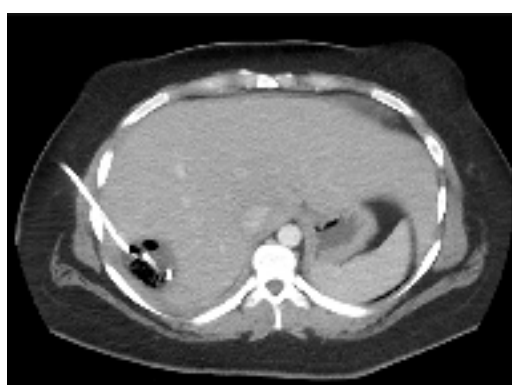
Follow-up computed tomography. The gas pocket reduced.
